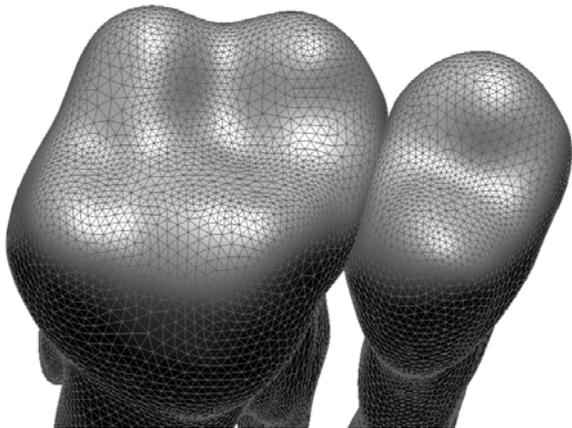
Models of occlusal surfaces of two teeth, created by data of computed tomography scanning
